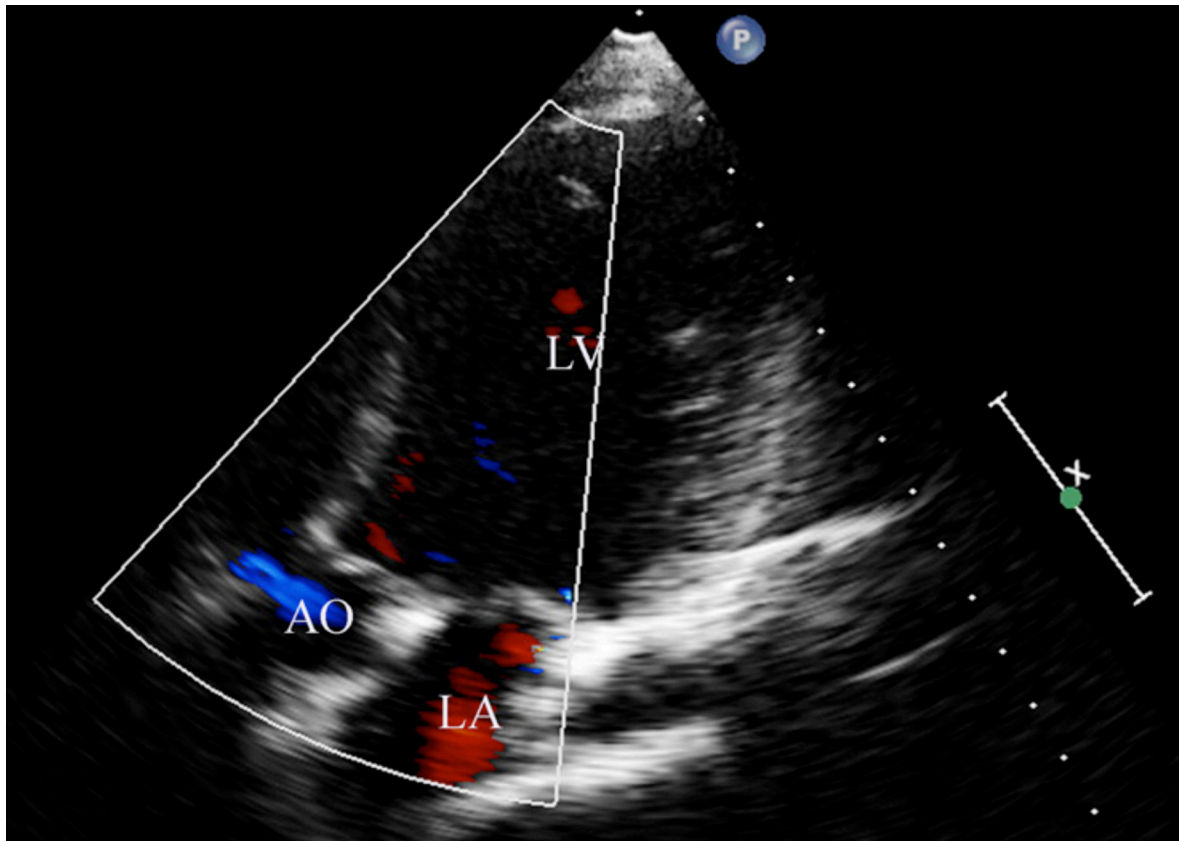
A color Doppler evaluation showed no residual aortic regurgitation. LV indicates the left ventricle postoperatively; LA, left atrium; AO, aorta.
